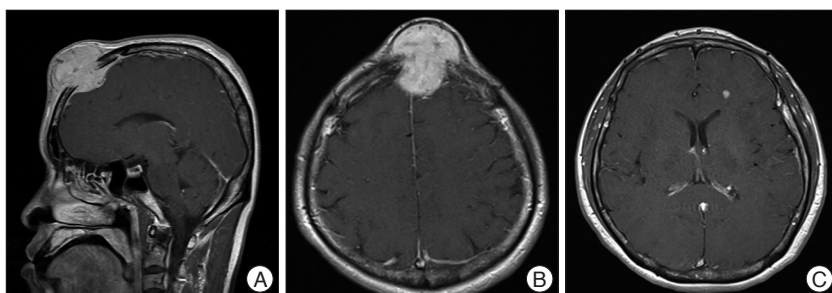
Magnetic resonance images of the patient with ASPS metastases to both the skull and the brain. A and B : The T1-weighted-enhanced sagittal and axial images reveal an osteolytic mass lesion on the frontal bone. C : The T1-weighted-enhanced axial image reveals a well-enhanced lesion in deep white matter on the left frontal lobe. ASPS : alveolar soft part sarcoma.
